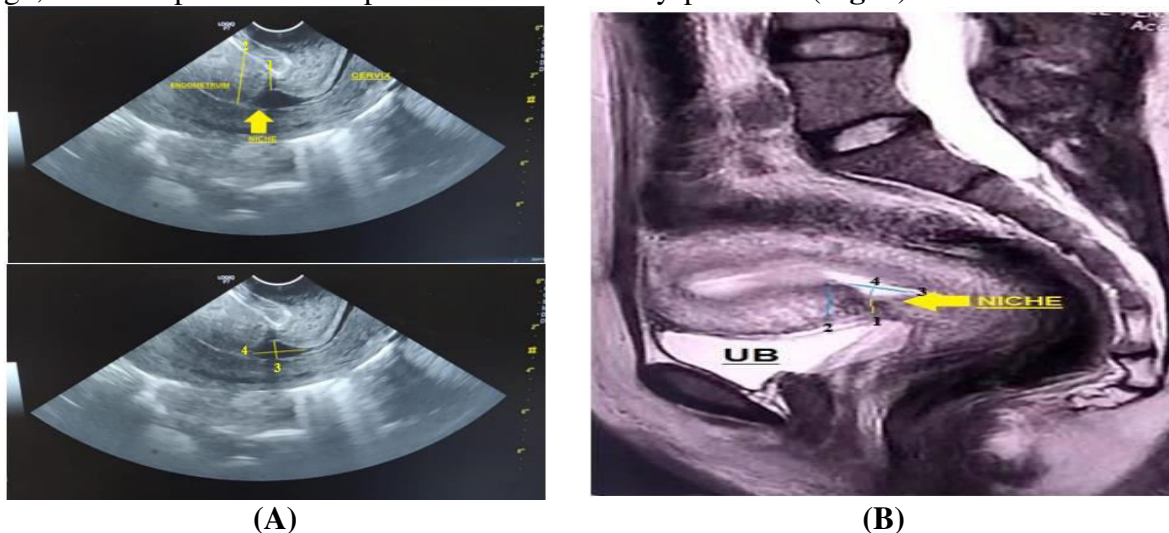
(A) TVUS show TVUS revealed anechoic area at the isthmus at the site of previous scar, 1. residual myometrial thickness: 3.1mm, 2.AMT:13.mm, 3.Depth: 5.8mm, 4.Length: 6.5mm ,(B) MRI pelvis of sagittal T2 WI with triangular area of myometrium defect directed anteriorly to urinary bladder ,Niche is detected, 1.RMT:4.2m, 2.AMT:14mm, 3.Length:7.5mm, 4.Depth: 6.5mm
